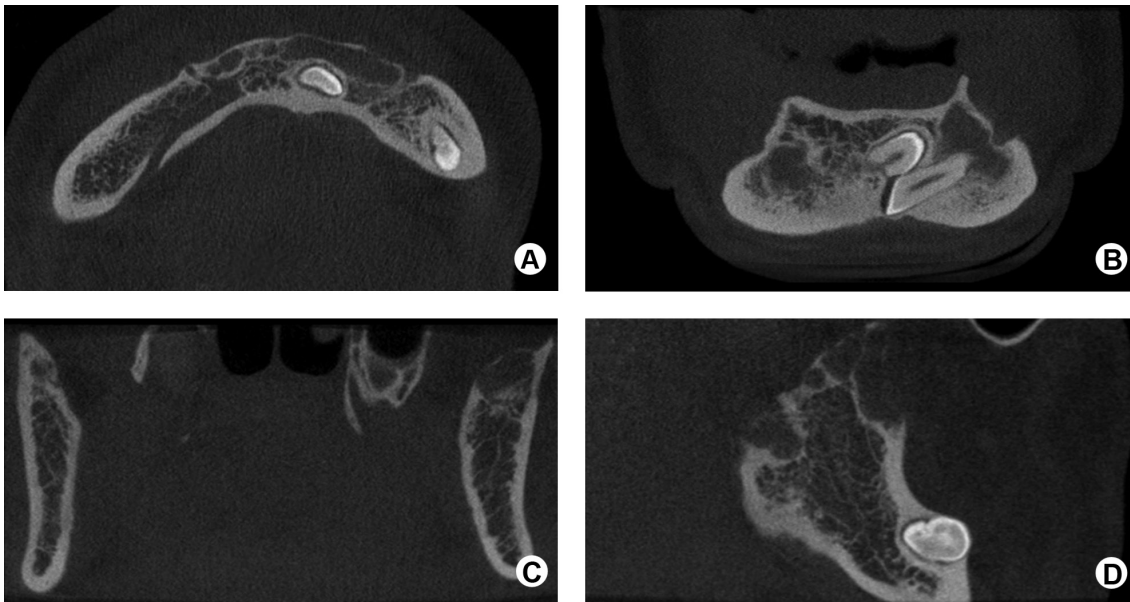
CBCT axial (A), coronal (B and C) and sagittal (D) scans showing osteolytic lesions extending from the base to the mandibular ramus, causing bone loss and displacement of teeth to the base of the mandible.
